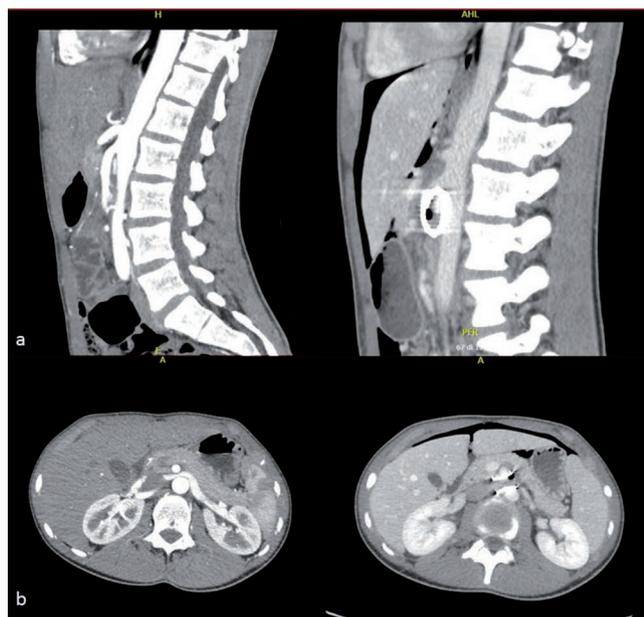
Patient 1: pre and post-operative CT scan (a. sagittal and b. transverse sections) showing correct ES position and resolution of LRV stenosis.
